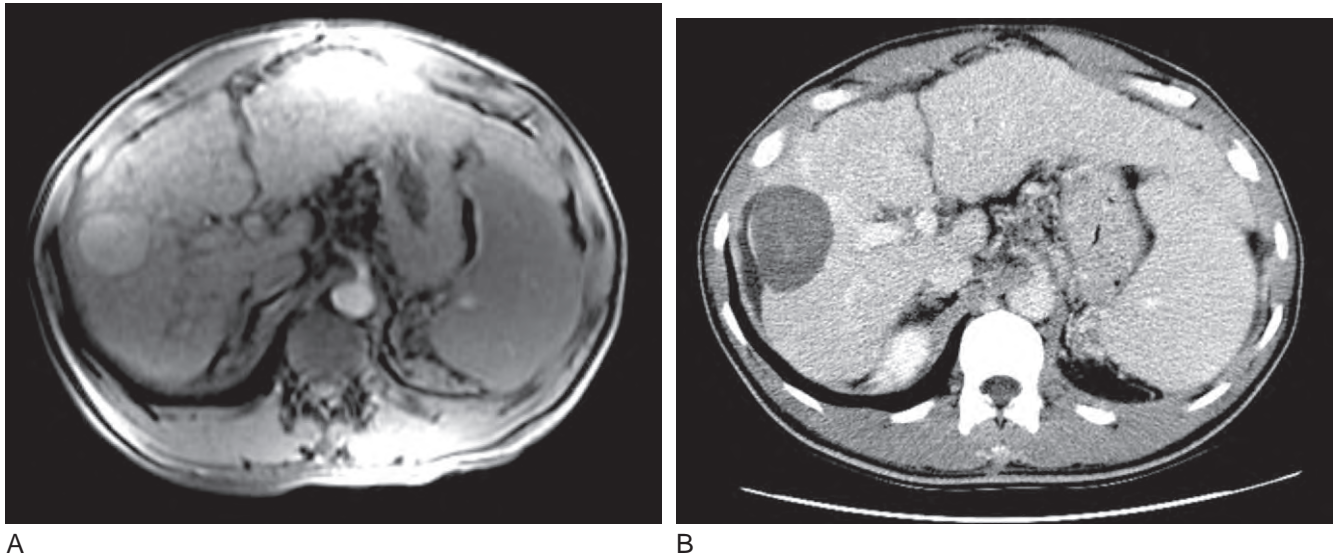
Hepatocellular carcinoma before (A, MRI) and after (B, CT scan) radiofrequency ablation.
